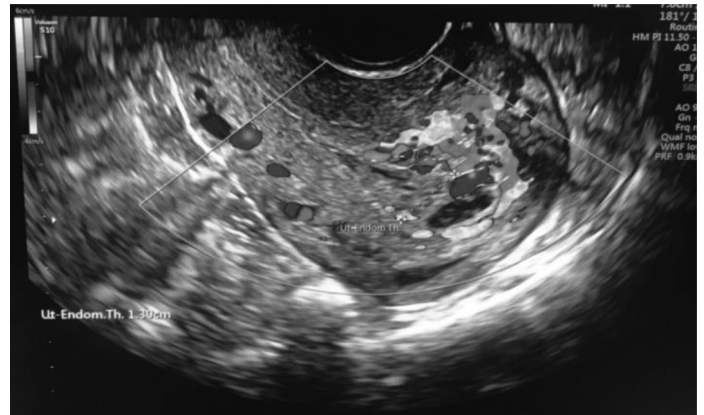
Repeat transvaginal sonogram revealed normal sized uterus, retroverted, measuring 5.23 x 5.31 x 5.53 cm with cervix measuring 3.99 x 2.29 x 2.77 cm. The endometrium is thickened at 1.3 cm, with cystic spaces, midline echoes not defined. The endomyometrial junction at the posterior mid to upper segment is interrupted by dilated myometrial vessels with abundant and turbulent color flow on mapping
